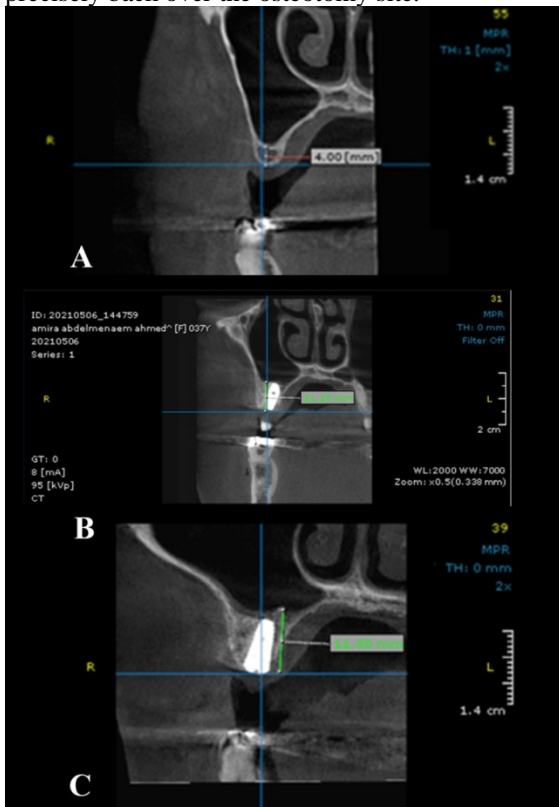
A) Cross-sectional CBCT showing preoperative vertical bone height equals 4 mm. B) Cross-sectional CBCT after 3 months showing vertical bone height equals 11.15 mm. C) Cross-sectional CBCT after 6 months showing vertical bone height equals 11.80 mm.
